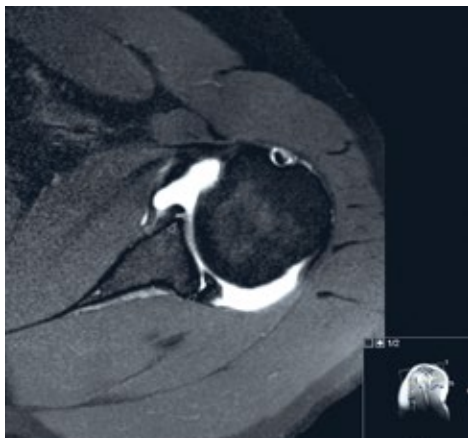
Example of an extensive labrum lesion (axial orientation, T1-weighted): avulsion of the anterior-inferior labrum from the anterior-inferior rim of the glenoid (long arrow) extended to posterior-inferior (short arrow)
